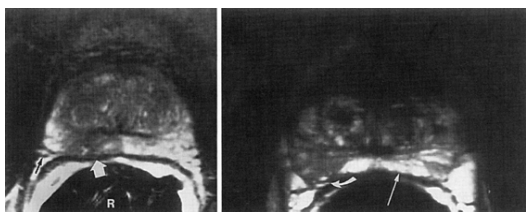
24. Endorectal coil magnetic resonance imaging scan showing stage B prostate cancer. A transverse section demonstrates the thick Denonvilliers' fascia (*white arrows*). The tumor, which is low in signal intensity, can be seen in the background of the high-signal-intensity peripheral zone. The neurovascular bundle (*black arrow*) is spared. R, rectum. (Courtesy of Dr. Ronald M. Summers, NIH.)
